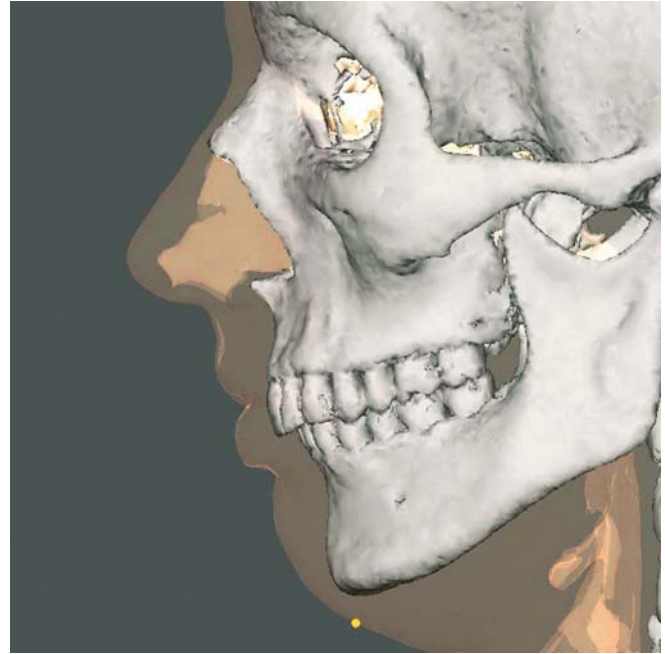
Soft tissue gnathion. Profile view left (3-D CT, transparent soft tissues, patient K.C.)
